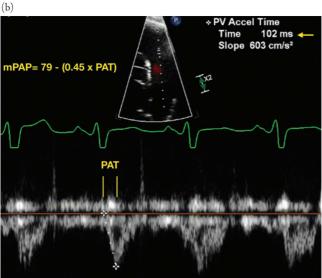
(a) Pulmonary artery diastolic pressure (PADP) estimation. A pulmonic valve regurgitation jet must be visualized to calculate PADP. There is an early and end-diastolic peak; use the V_{max} of, or pressure gradient associated with, the end-diastolic peak (arrows) to calculate PADP. Right atrial pressure (RAP) is estimated with inferior vena cava respirophasic variability. Adapted from Figure 3 of Parasuraman S, Walker S, Loudon BL, et al. Assessment of pulmonary artery pressure by echocardiography: a comprehensive review. *Int J Cardiol Heart Vasc.* 2016;12:45–51. (b) Pulmonary artery velocity acceleration time (PAT). *Image courtesy of Drs. Anthony Koppula, MD, and Robin Wachsner, MD, Division of Cardiology, Department of Medicine, Olive View–UCLA Medical Center, Los Angeles, CA.*
